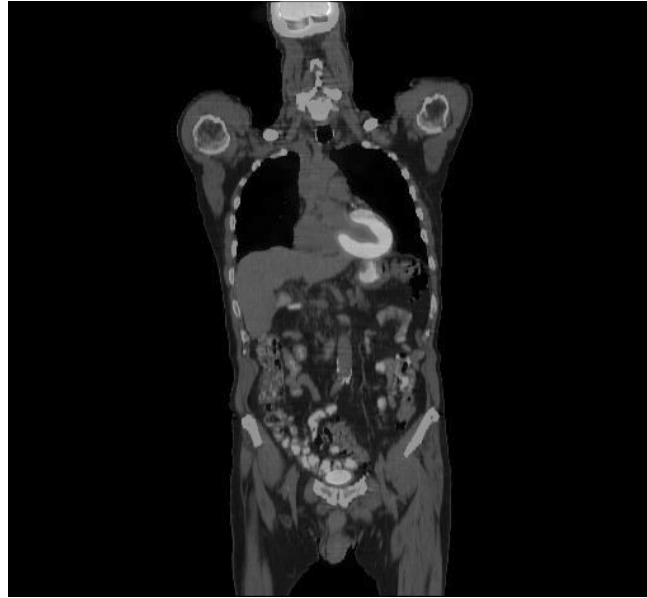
Reconstructed image showing fusion of both CT image data and positron emission tomography (PET) image data into a single image. Note that PET image data shows physiological function while the CT image data shows the anatomical features. Tools allow the user to dynamically change how much PET or CT data is displayed in the fused image. Note the areas in the body such as the heart with high activity signal from the acquired PET data.
